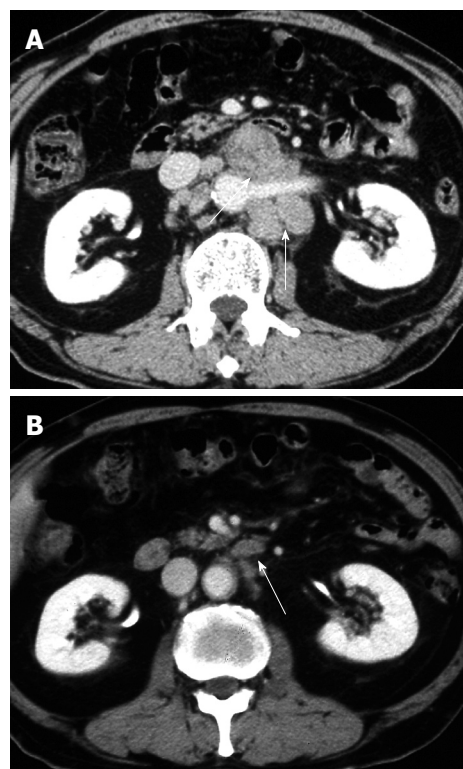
Abdominal computed tomography (CT). A: Marked swelling of paraaortic lymph nodes before treatment (arrow); B: After two courses of S-1, abdominal CT showed remarkable reductions (arrow).
